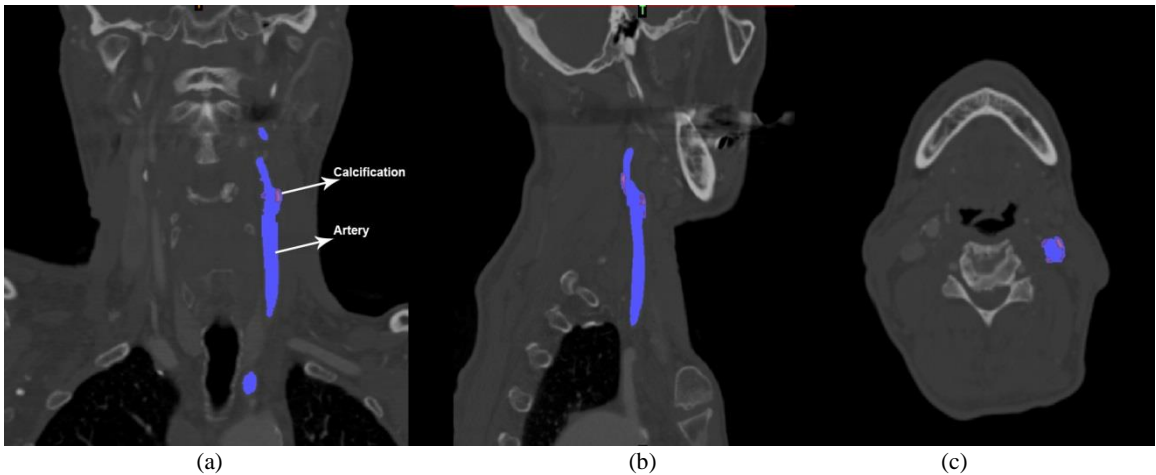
CT image belongs to a case where left carotid artery along with the calcifications are visible. Both artery and the calcified plaque are segmented for further construction in coronary (a), sagittal (b) and axial view (c).
